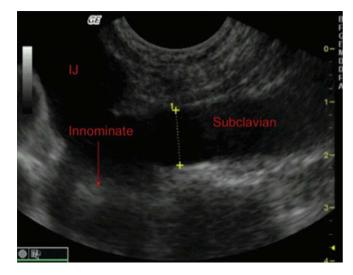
Ultrasound visualization of subclavian and innominate veins. IJ = internal jugular vein. Adapted from Figure 1 of Mallin M, Louis H, Madsen T. A novel technique for ultrasound-guided supraclavicular subclavian cannulation. *Am J Emerg Med.* 2010;28(8):966–969. doi:10.1016/j.ajem.2009.07.019.
